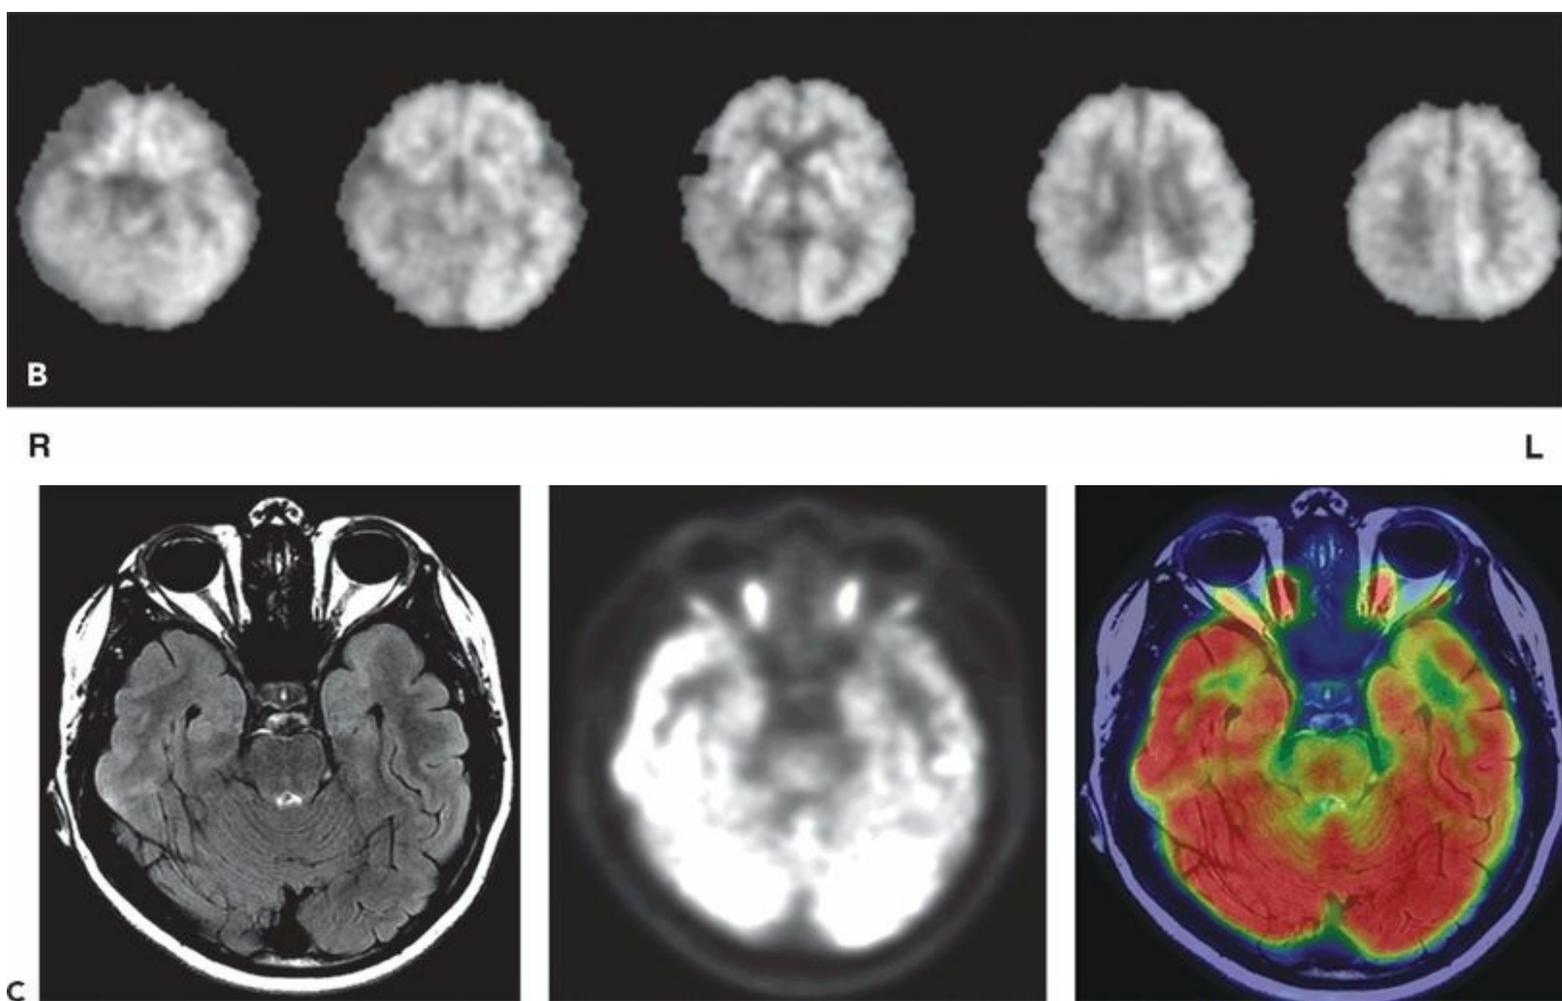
A: [^{18}F]FDG-PET in an adult with left TLE showing decreased glucose uptake in mesial temporal regions following partial volume correction. (Courtesy of Dr. William H. Theodore. National Institutes of Health, Bethesda, Maryland.) B: [^{18}F]FDG-PET scan in a 14-month-old child with focal seizures (right posterior quadrant focus), secondary generalization, and normal MRI. Figure shows right posterior quadrant hypometabolism. C: [^{18}F]FDG-PET scan of a 15-year-old female, with focal epilepsy with altered consciousness, who has subtle left anterior mesial tip temporal focal cortical dysplasia (MRI) and widespread decrease in hypometabolism (PET). MRI, PET, and coregistered PET/MRI are shown. Left image is the right brain. (National Institutes of Health, Bethesda, Maryland.)
